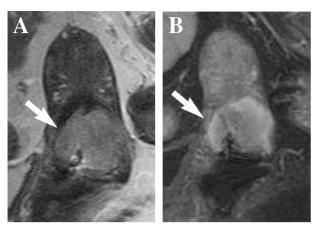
Cervical adenocarcinoma in a 61 year-old woman. Sagittal (A) preoperative T2-weighted (B) and contrast enhanced T1 weighted MR images show an ovoid, heterogeneous tumor (arrow) distending the cervical canal with stromal involvement. This is a classic image of cervical adenocarcinoma, which biopsy also proved to be cervical adenocarcinoma with stromal invasion.
